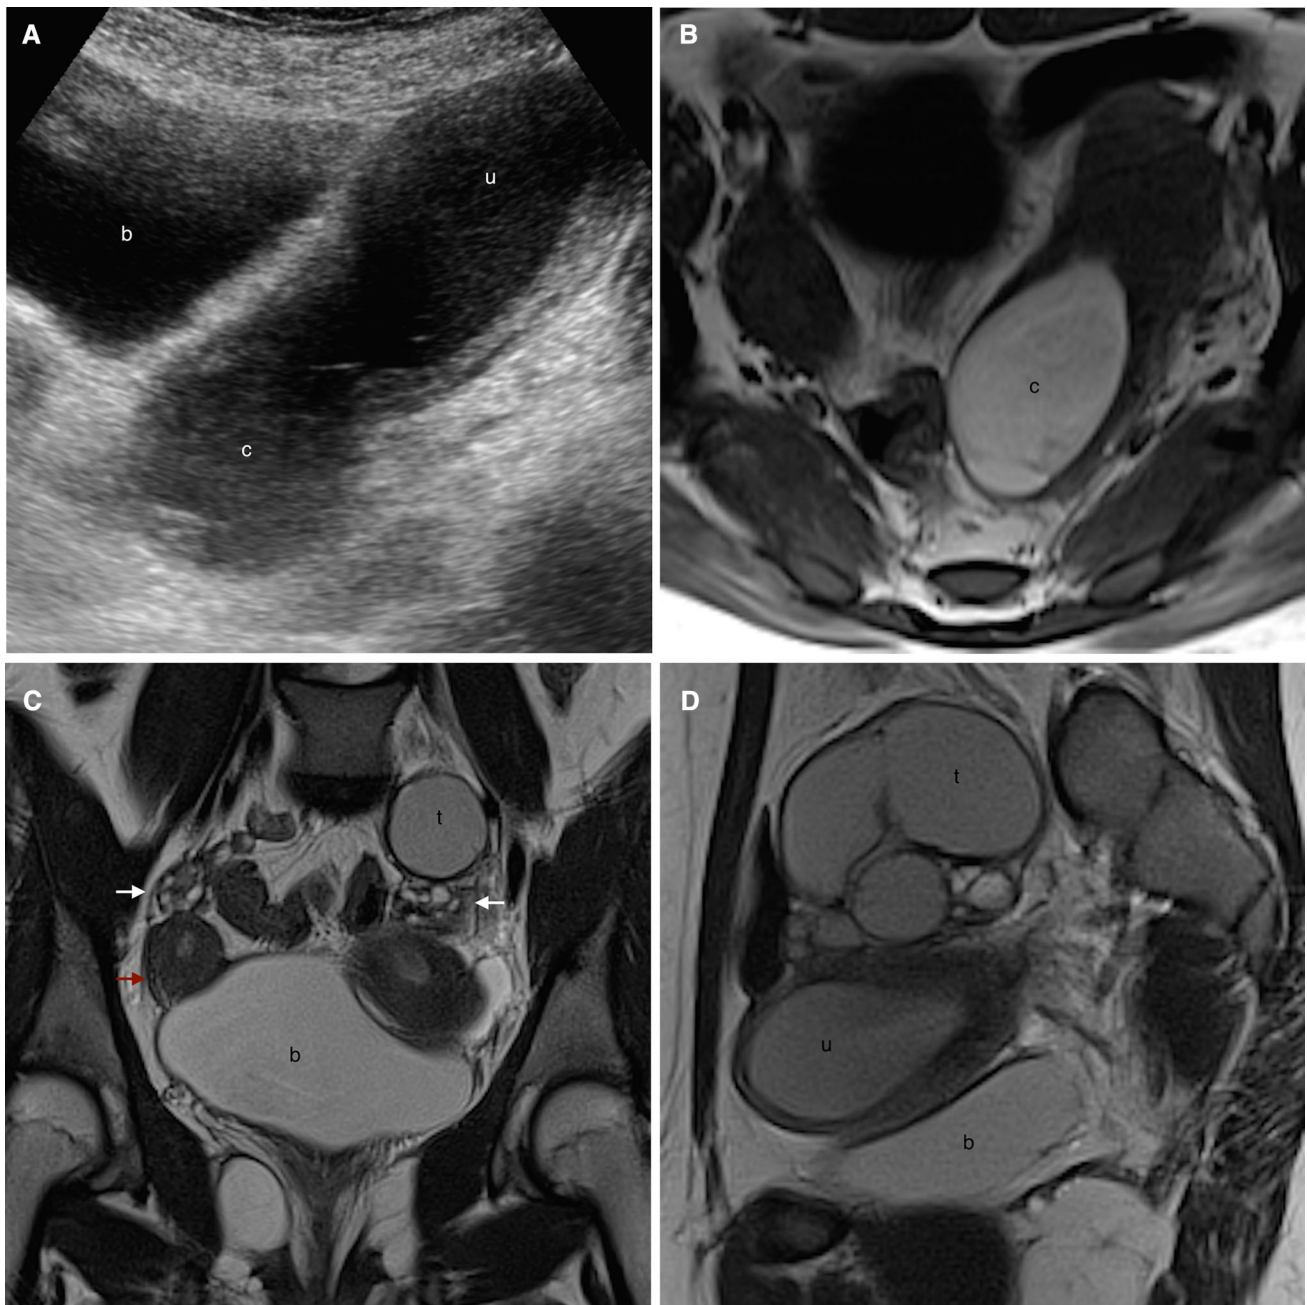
Images in a 12-year-old girl who presented to the emergency department with a 1-month history of severe dysmenorrhea (A US; B axial T1WI; C coronal T2WI; D, E sagittal T2WI; G axial T2WI; H sagittal T2WI). US revealed the absence of the left kidney (not shown) and a pelvic, thick-walled tubular structure with heterogeneous, mixed echogenicity, and posterior enhancement (A). MRI showed a uterus didelphys with a non-dilated right horn (C red arrow) and left hematocolpos (*v*), hematocervix (*c*), hematometra (*u*), and hematosalpinx (*t*). Blood appeared hyperintense on T1WI (B) and slightly less intense on T2WI (C–E). The hematocolpos essentially involved the upper vagina and was heterogeneous and lobulated, suggesting co-infection. Both ovaries were
